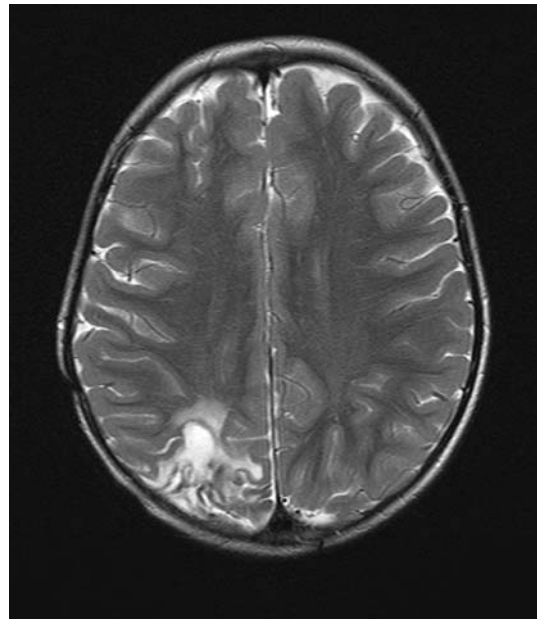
The most recent MR imaging (axial, T2 weighted) at 25 months after diagnosis shows some nodular enhancement at the surgical bed which has gradually improved while off therapy. There is no definitive evidence of disease at this time
